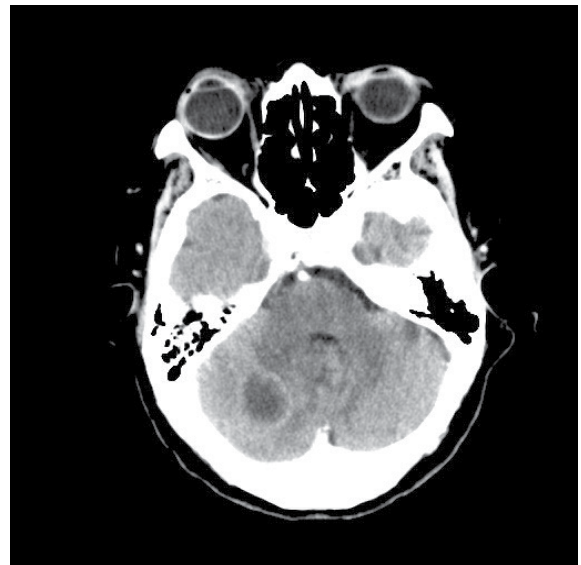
Contrast enhanced brain computed tomography showed a hypodense lesion with rim enhancement over the superior vermis and right cerebellum.
